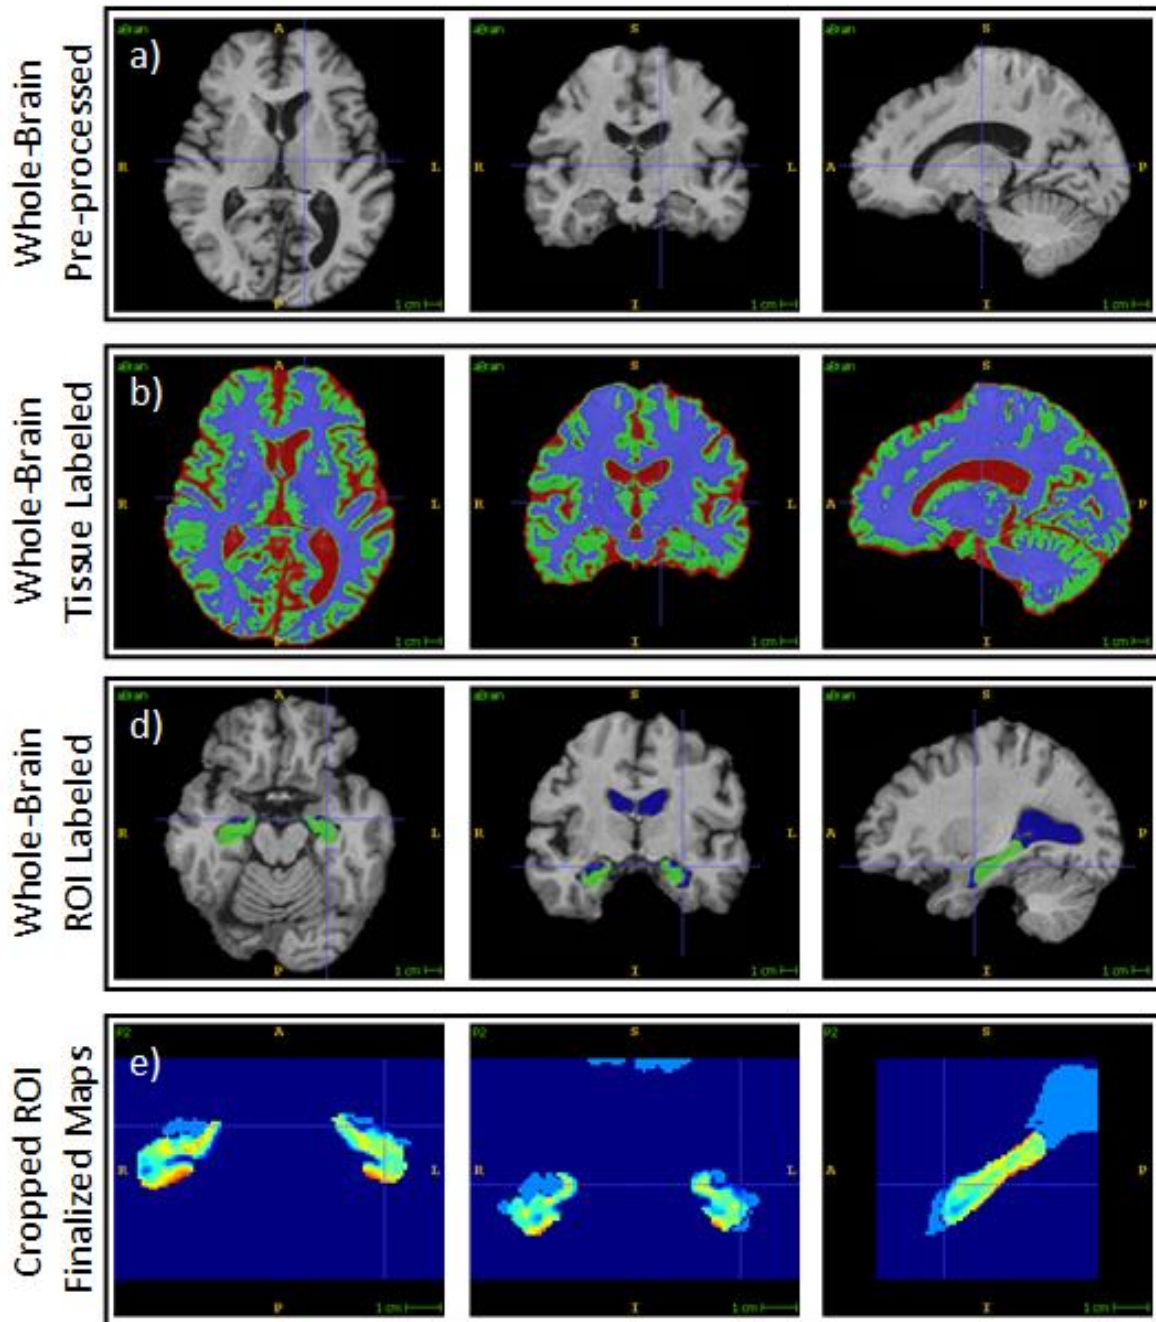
Axial, sagittal, and coronal view respectively left to right in a head scan from a single-subject MRI session along with all resulting images from the necessary processes.
